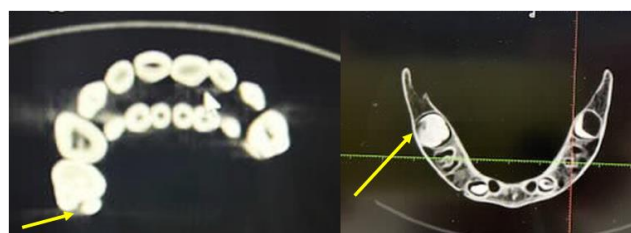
CT slices of the affected primary molars.
